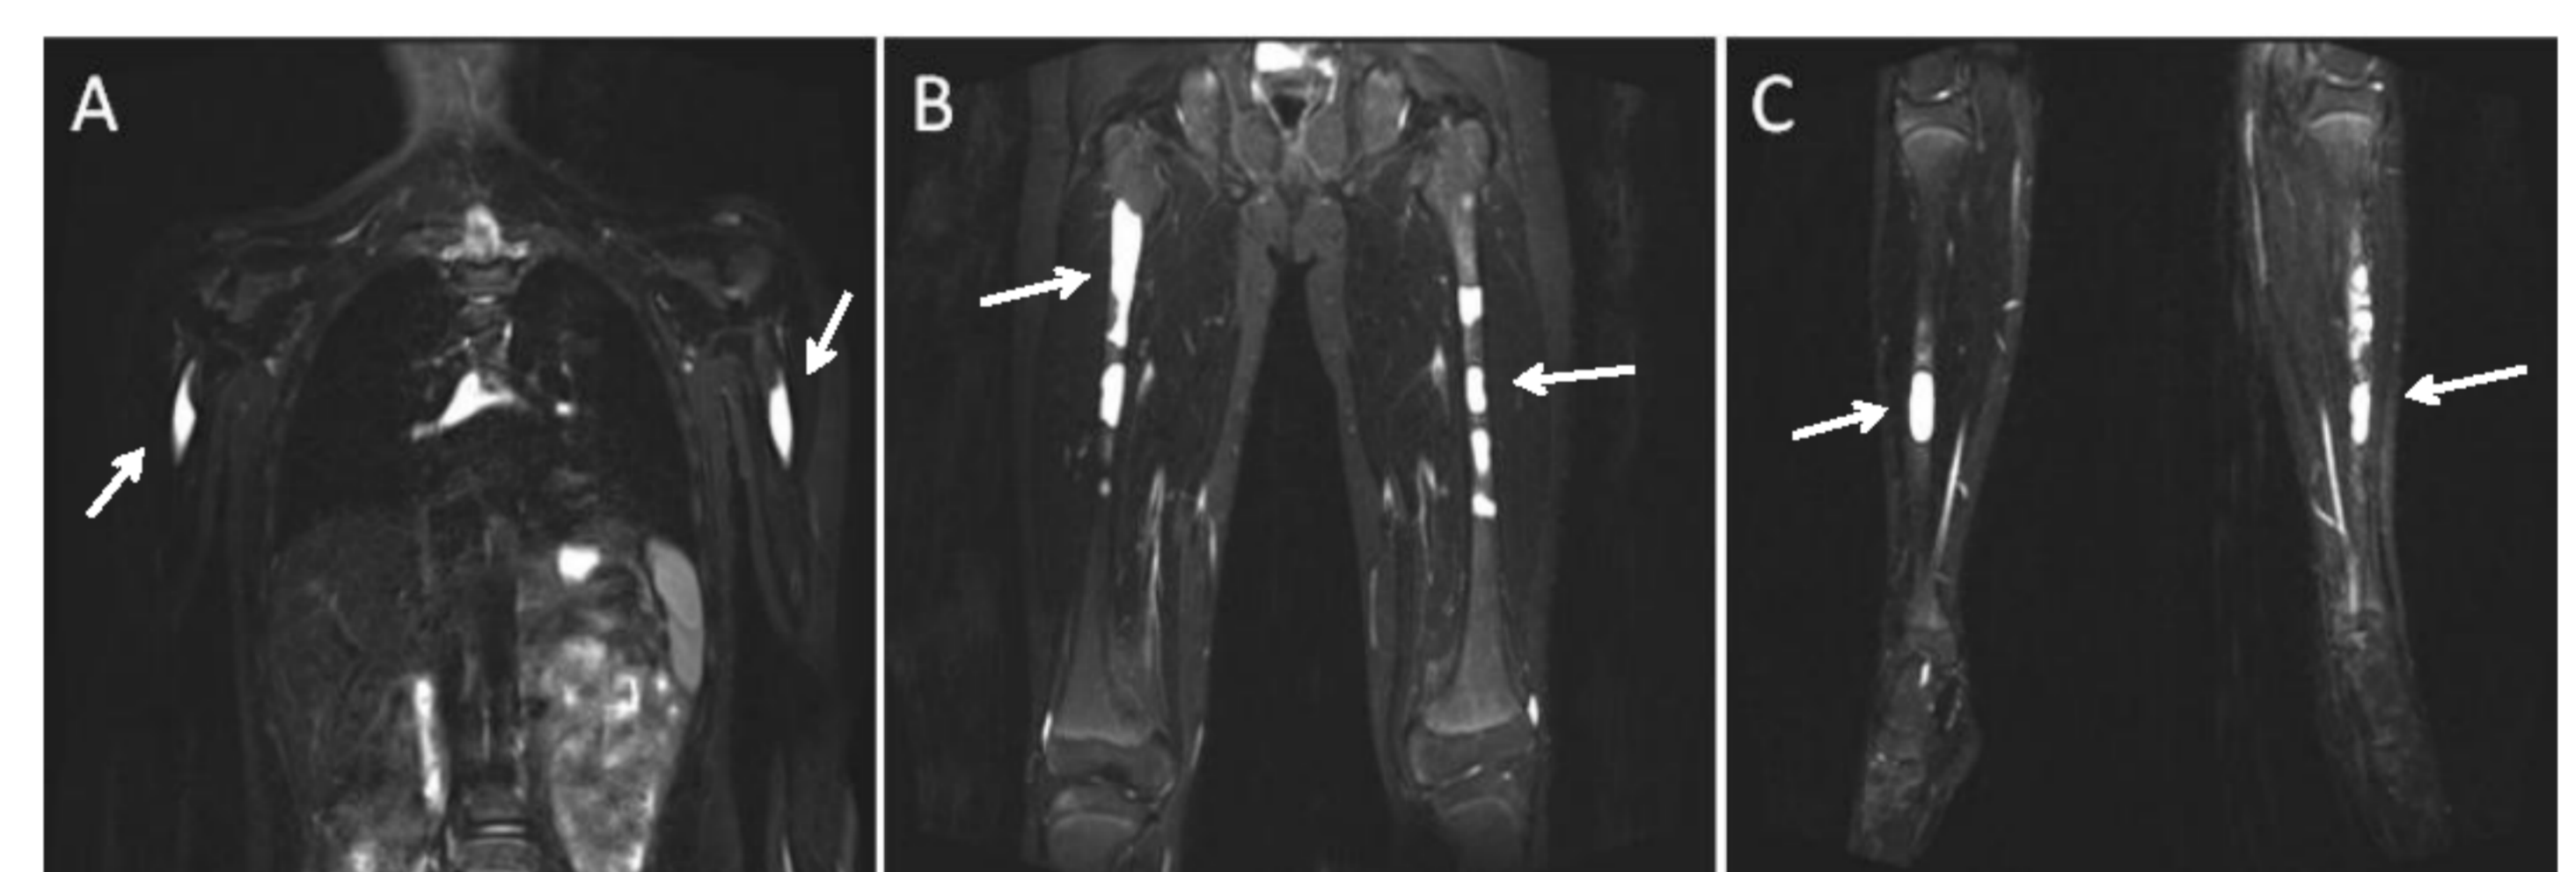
T2-weighted fat saturated MRI images of a 16-year-old boy has several cysts (depicted in white) in both humeri (A), femora (B), and tibiae (C).
